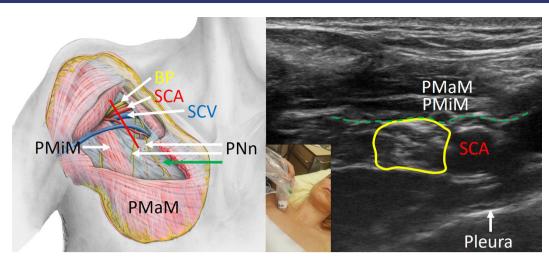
Anatomy of the infraclavicular region including an ultrasound cross-section. The position of the ultrasound probe is indicated by the red line. The brachial plexus (at the level of the cords) in the ultrasound image is encircled by the yellow line and the clavipectoral fascia is indicated by the green line. BP, brachial plexus; PMaM, pectoralis major muscle; PMiM, pectoralis minor muscle; PNn, pectoral nerves; SCA, subclavian artery; SCV, subclavian vein.
